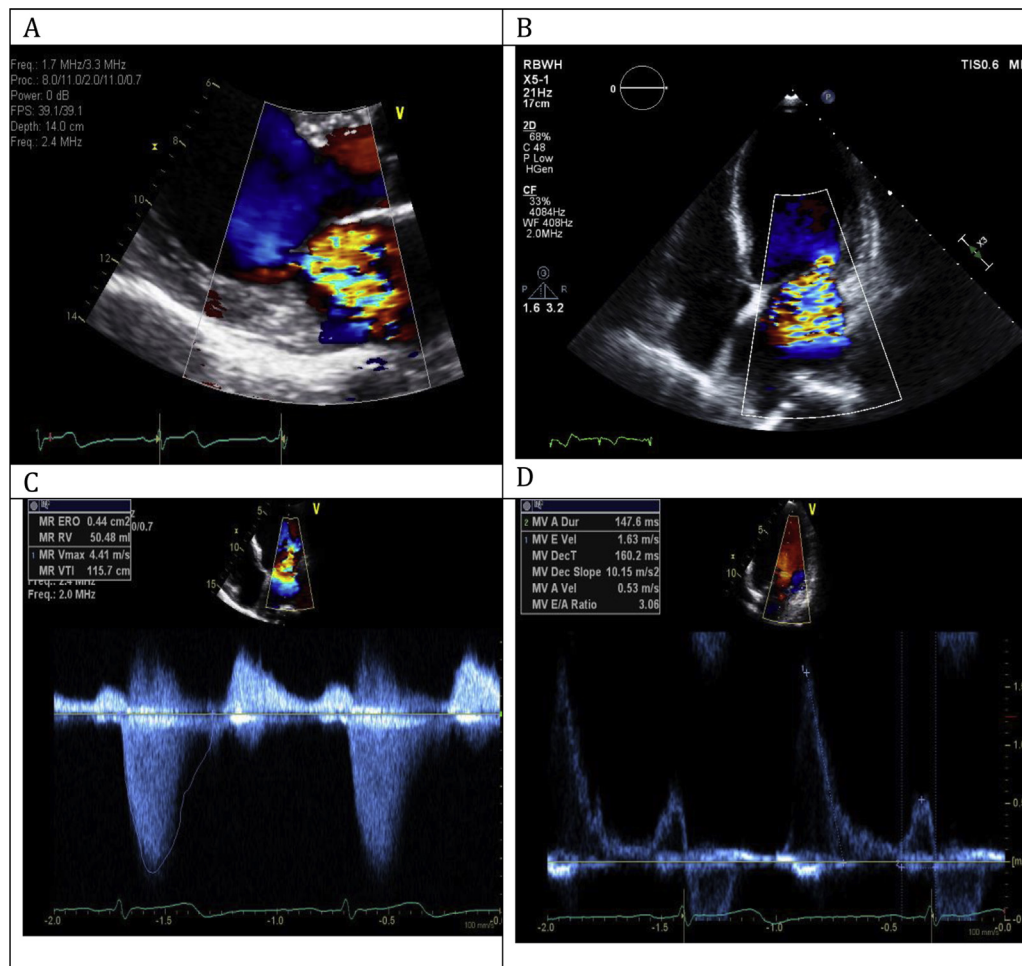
Severe MR on Doppler echocardiography. (A, B) Color Doppler showing a broad, eccentric regurgitant jet in parasternal long-axis and apical four-chamber views. (C) Continuous-wave Doppler showing dense MR envelope with V cutoff sign. (D) Pulsed-wave Doppler showing elevated E-wave velocity consistent with severe MR.
